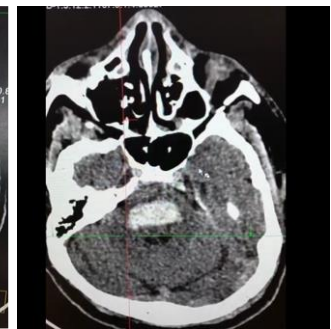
Preoperative CT scan of brainstem hematoma
